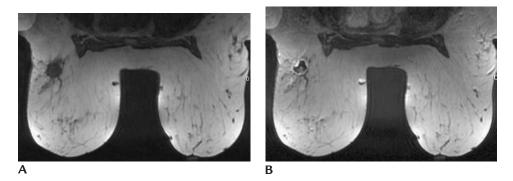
Invasive ductal carcinoma. (A) T1-weighted axial image pre-contrast. (B) T1-weighted axial immediately post-contrast bolus. Round mass with well-circumscribed margins. Low signal intensity pre-contrast. Rim enhancement post-contrast; rapid initial enhancement and wash out.
